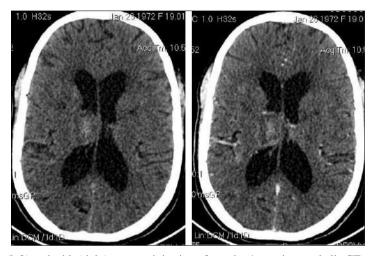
Axial section without (left) and with (right) contrast injection of a patient's cranioencephalic CT scan showing a spontaneously moderately hyperdense formation of the body of the right caudate nucleus massing on the right lateral ventricle and not taking contrast after contrast injection in relation to a resorbing hematoma of the right caudate nucleus body.
